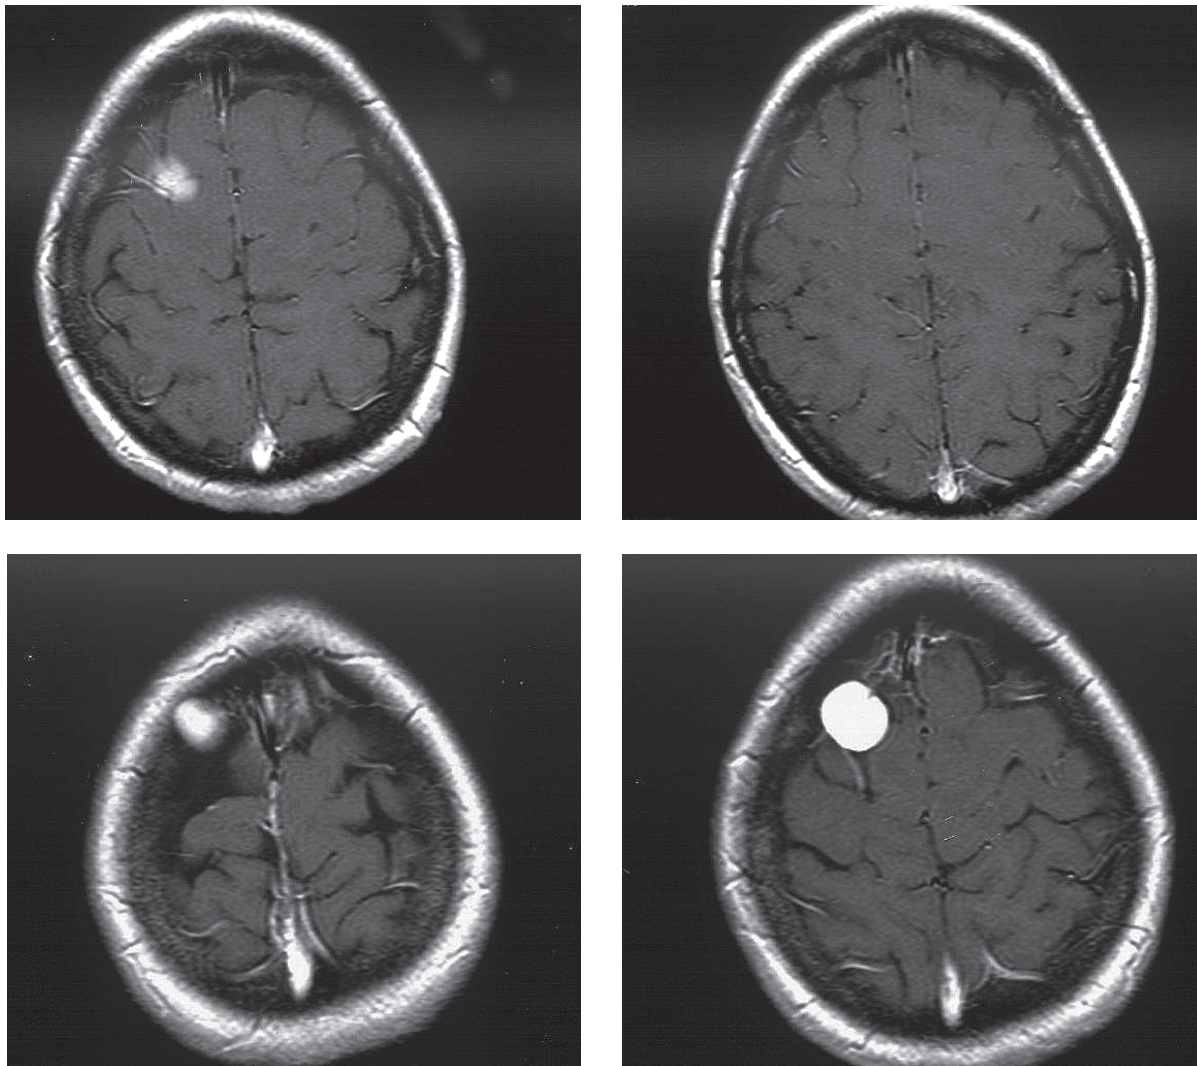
MRI with contrast medium. The Varix is displayed precentrally on the right side. No pathological vessel is visualized.
